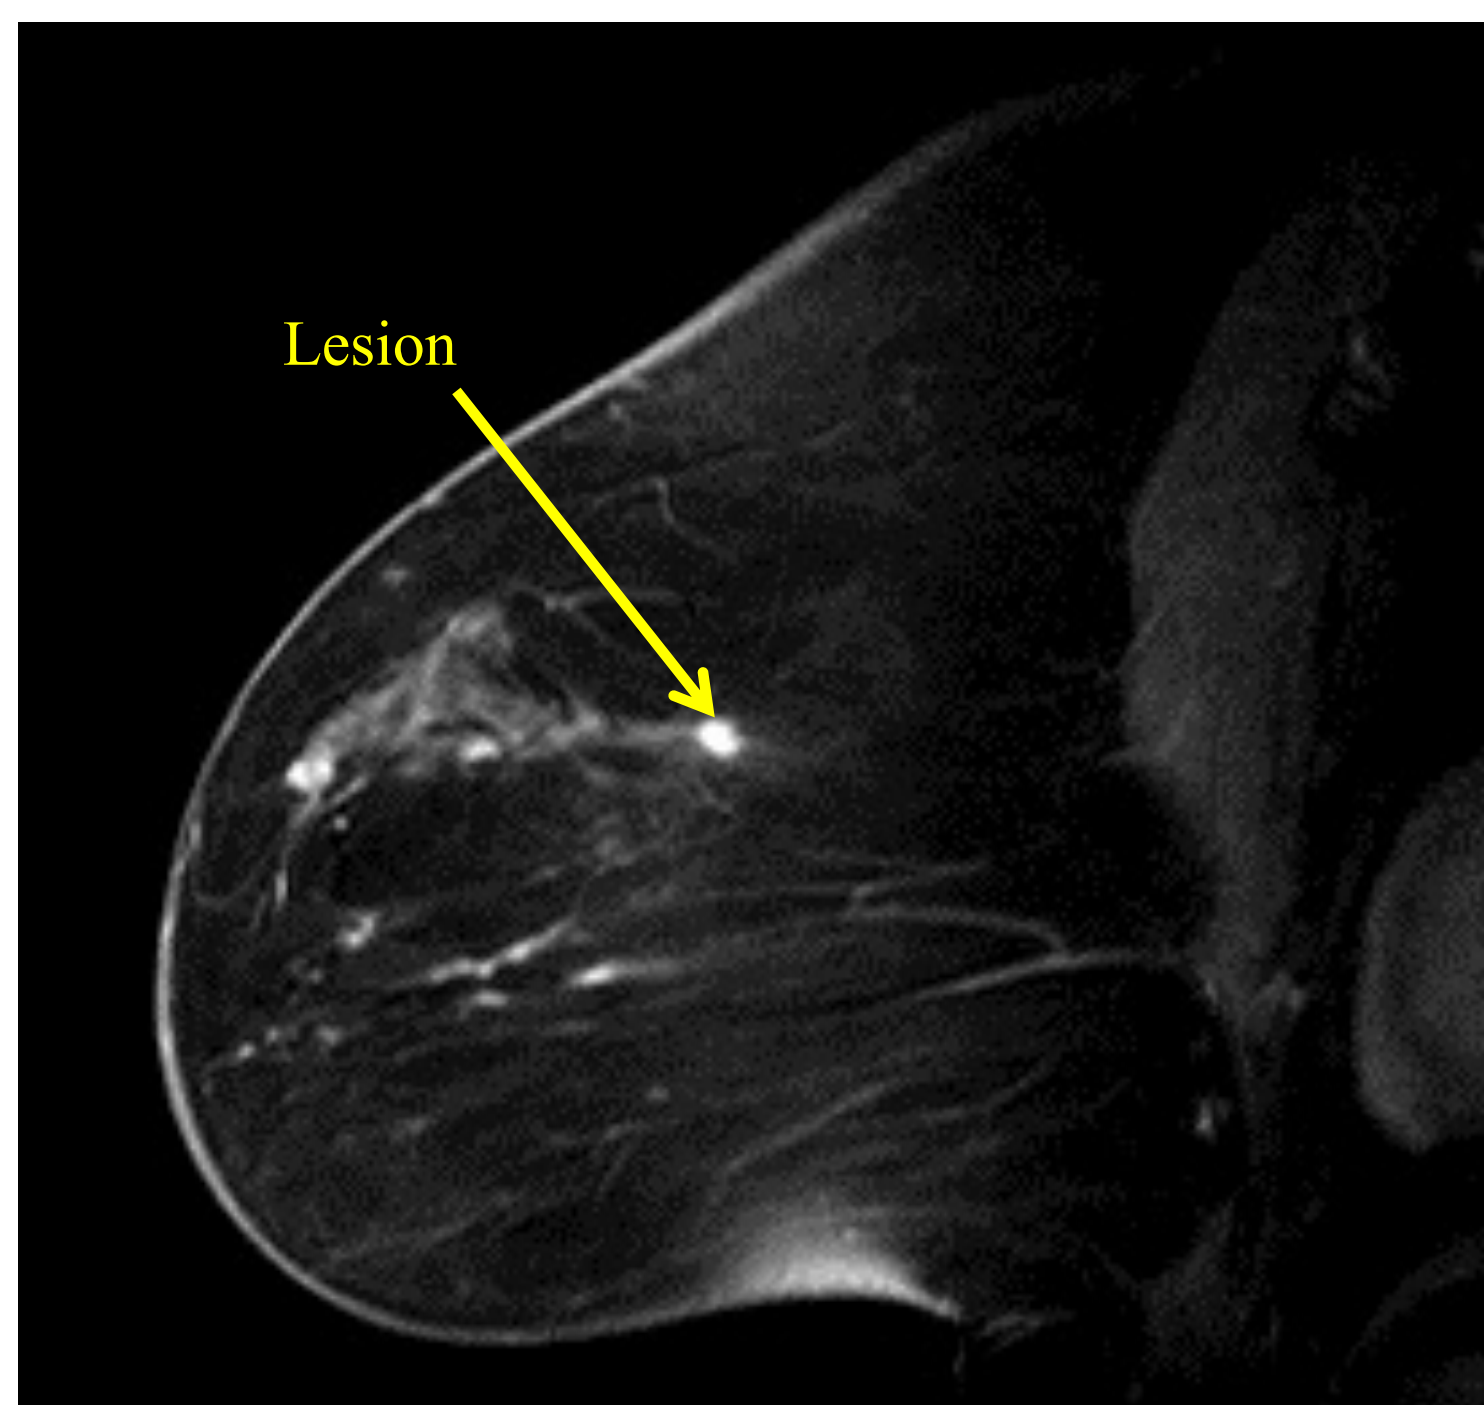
Sagittal T1W (T1-weighted) postcontrast delay (Adrada et al., 2022, slide 19)
